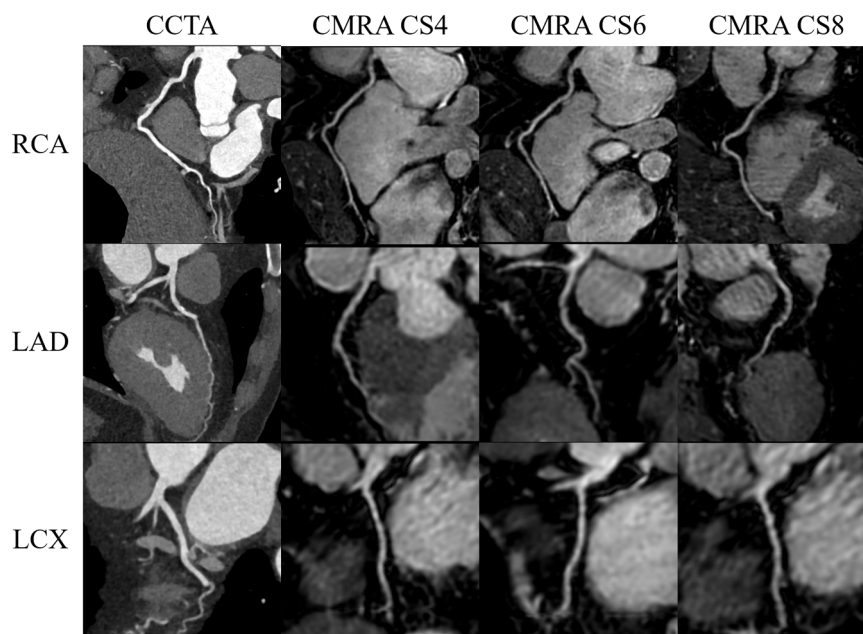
Comparison of coronary artery imaging by CCTA and CMRA with CS4, 6, and 8. The images come from a 66-year-old man with angina pectoris. The upper row is RCA, the middle row is LAD, and the lower row is LCX. CCTA, CMRA CS4, CMRA CS6, and CMRA CS8 images are sequenced from left to right. The image quality of CS8 is inferior to that of CS4 and CS6, exhibiting more jagged artifacts and lower coronary signal intensity. There is a slight stenosis of the proximal segment of the LAD. Abbreviations: RCA = right coronary artery; LAD = left anterior descending artery; LCX = left circumflex; CMRA = coronary magnetic resonance angiography; CCTA = coronary computed tomography angiography; CS = compressed sensing.
